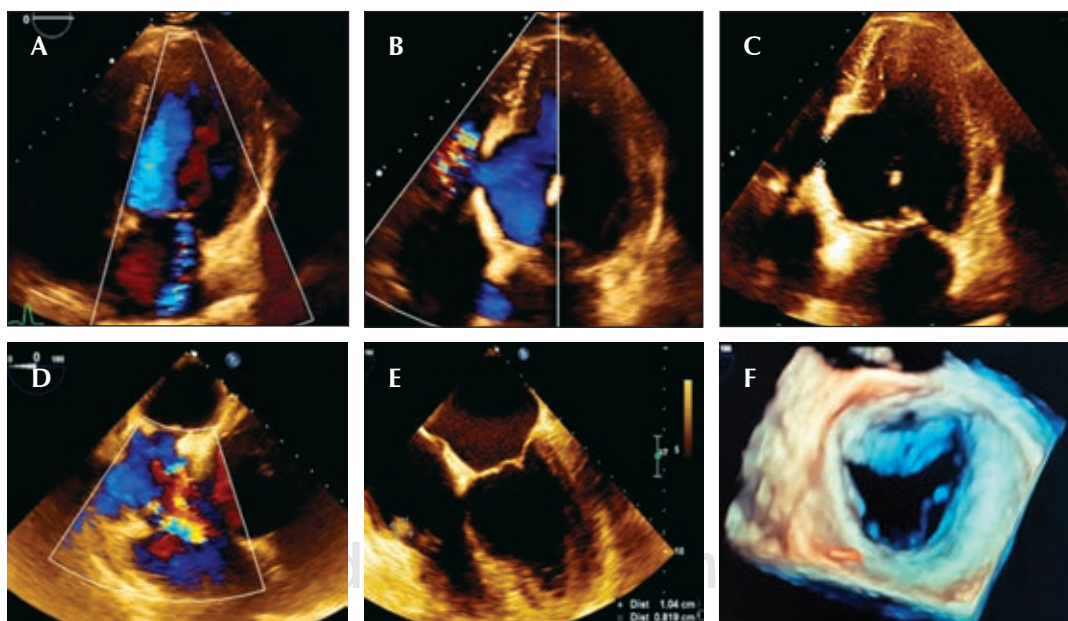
A) Transthoracic echocardiogram. Apical 4 chambers with Doppler color. Severe mitral regurgitation jet is observed. B) Apical 4 chamber Doppler color. Passage of flow through the ventricular septal defect is observed. C) Apical 4 chambers. Evidence of ventricular septal defect of 11 mm. D) Transesophageal echocardiogram with Doppler color. Ventricular septal defect is evident. E) Vegetation in the anterior tricuspid valve of 1.04 × 0.8 cm. F) 3D reconstruction of the mitral valve with tenting.
